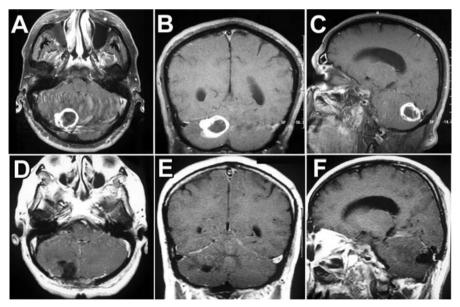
Posterior fossa metastases* are well demarcated from the surrounding cerebellar tissue. The tumor in the figure (A–C) was totally resected with a midline posterior suboccipital craniectomy (D–F). If the localization of the tumor is not evident on intraoperative imaging, intraoperative ultrasonography or navigation are helpful
